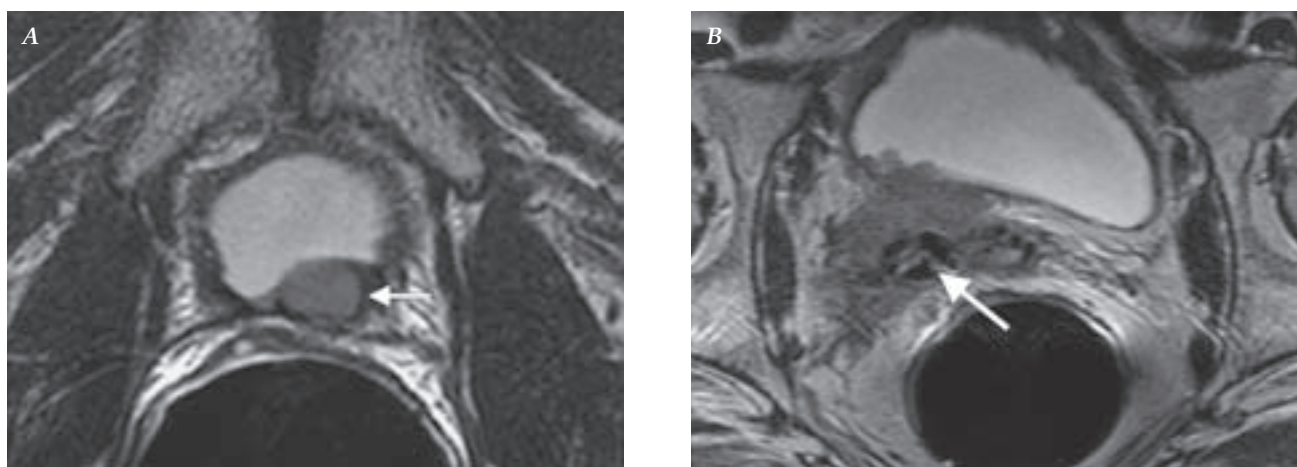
Endorectal MR images from two patients with prostate cancer recurrence after surgery. (A): Axial image shows a small lesion (arrow) at the bladder base. (B): Axial image shows a large tumor recurrence around three surgical clips (arrow).
